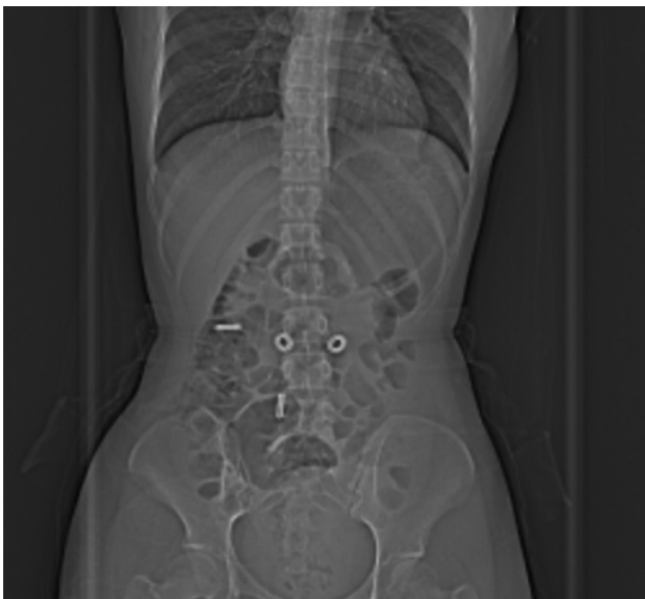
Follow-up CT scan obtained 1.5 years after surgery showing no evidence of recurrence or residual lesion. The abdominal and pelvic organs are in a normal anatomical position. This image demonstrates the favorable outcome following complete surgical excision.
